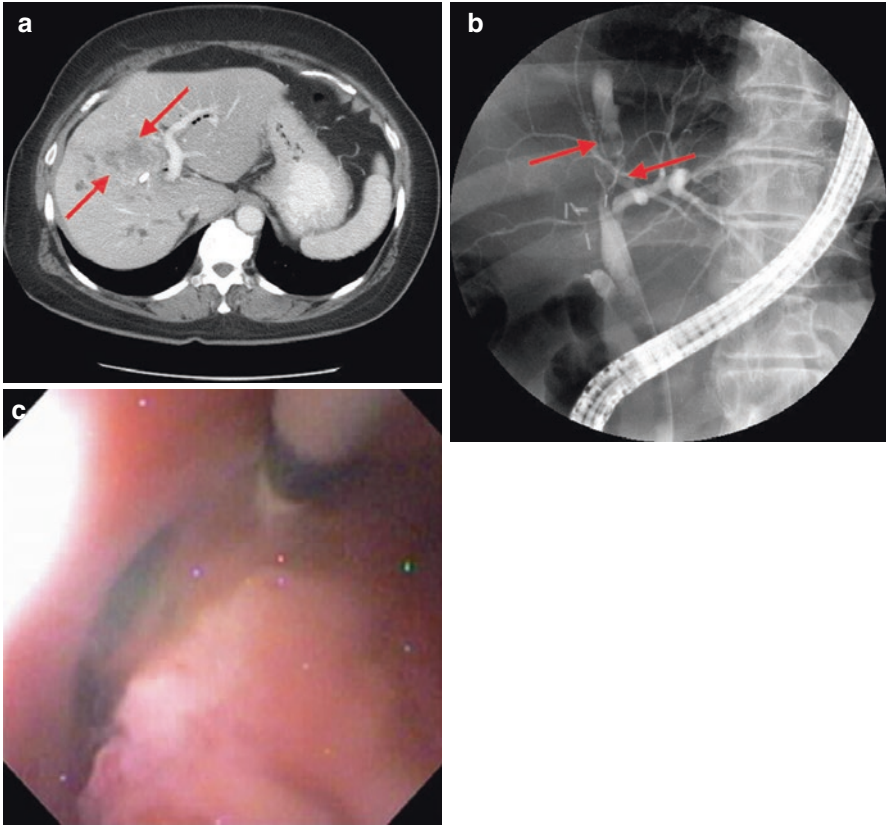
Bile duct adenomas seen in a patient with biliary papillomatosis. (a) In this CT image, note incomplete obstruction of the right intrahepatic system with biliary adenomas (arrows). (b) Findings at cholangiography show lack of contrast through the right intrahepatic duct and multiple adenomas leading to filling defects in the right duct and dilation of the left intrahepatic system (arrows). (c) Cholangioscopic view of biliary adenoma after wire access obtained in the left intrahepatic system
